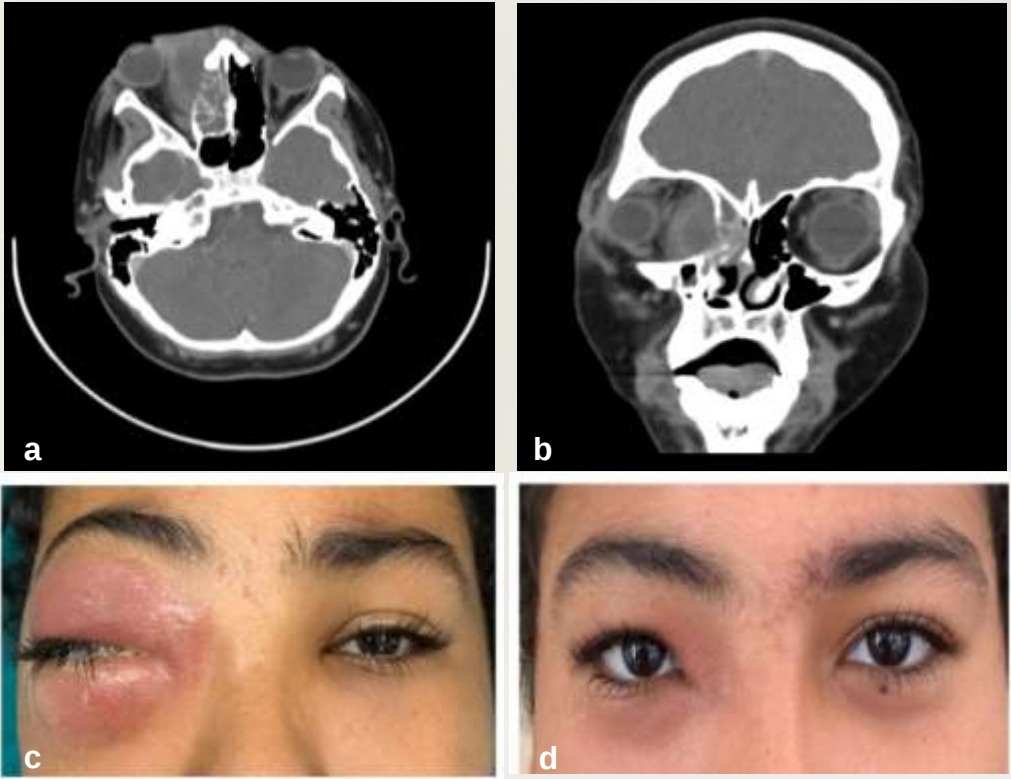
Subperiosteal abscess. (a,b) Axial and coronal CT scans of RT-sided medial subperiosteal abscess . (c,d) Pre- and post operative after ESS surgery.
